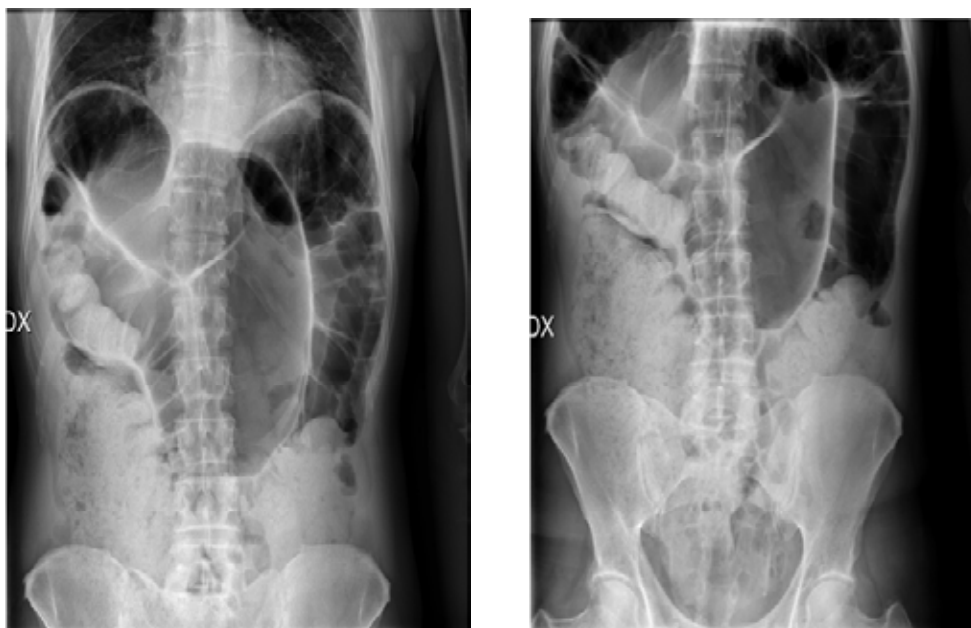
a-b. Abdomen radiography: gaseous overdistension of the sigma without gas in in the right and lower quadrants
